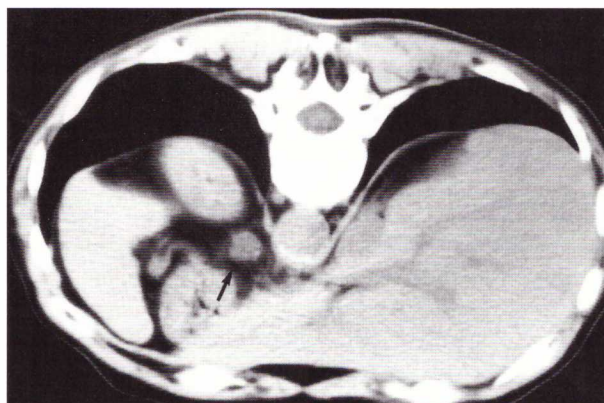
CT scan in prone position. An enlarged left adrenal gland is visualized (arrow), surrounded by lung, kidney, stomach, liver, and abdominal vessels.
